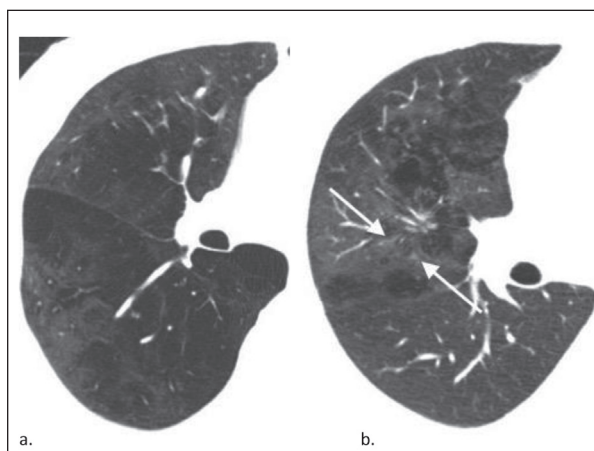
42-year-old male (a) and 26-year-old male (b), both non-smokers with PR3 positive ANCA associated vasculitis. Select axial HRCT images in lung window demonstrate low attenuation areas tracking along bronchovascular bundles. Additional ground-glass surrounds regions of LAA in the 26-year-old patient (arrows).
